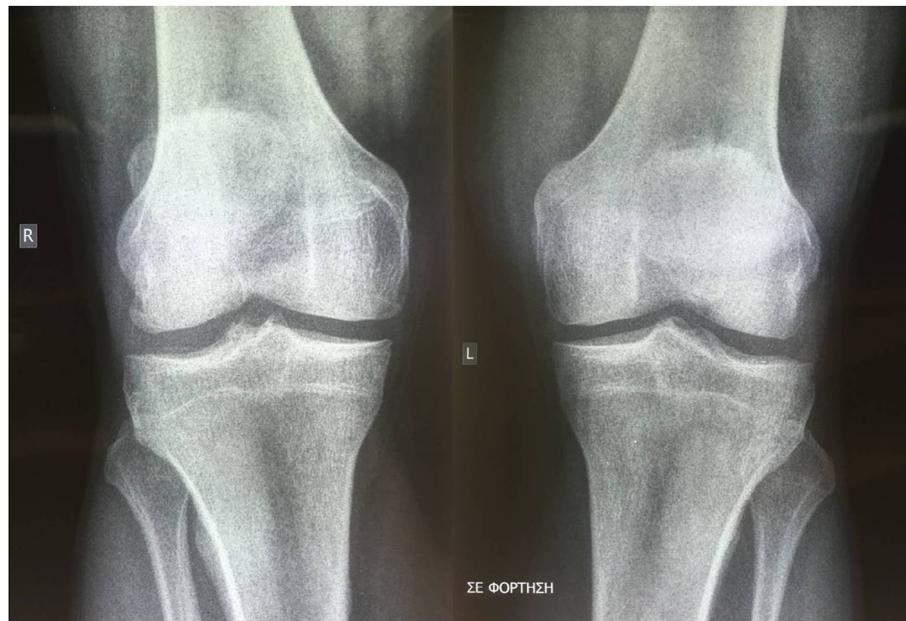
Antero-posterior weight-bearing radiography of knee showing the low position of the patella (left knee) associated with quadriceps tendon rupture.
